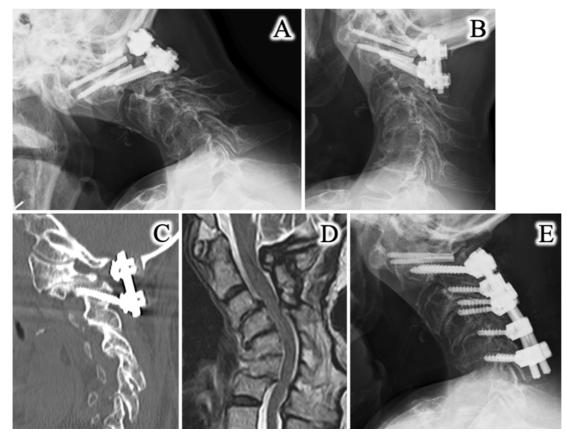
(A) (B) X-rays (lateral view) of cervical flexion and extension before the second operation. (C) CT before the second operation showing the erosion of the occipital bone. (D) T2-weighted MRI before the second operation showing C3 subluxation and canal stenosis. (E) X-ray after the second operation.
